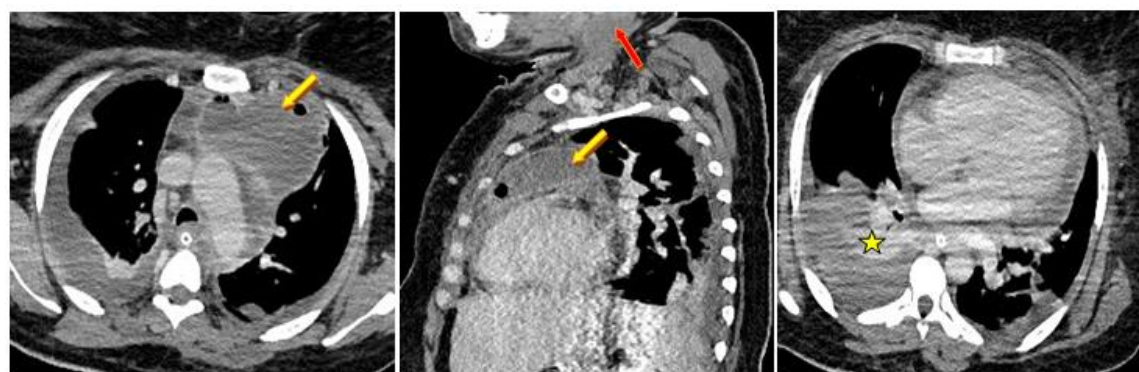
Control CT scan on day 10: increasing mediastinal collections (yellow arrows), decreasing cervical collections (red arrow), pleural effusion + pulmonary condensation (yellow star)
